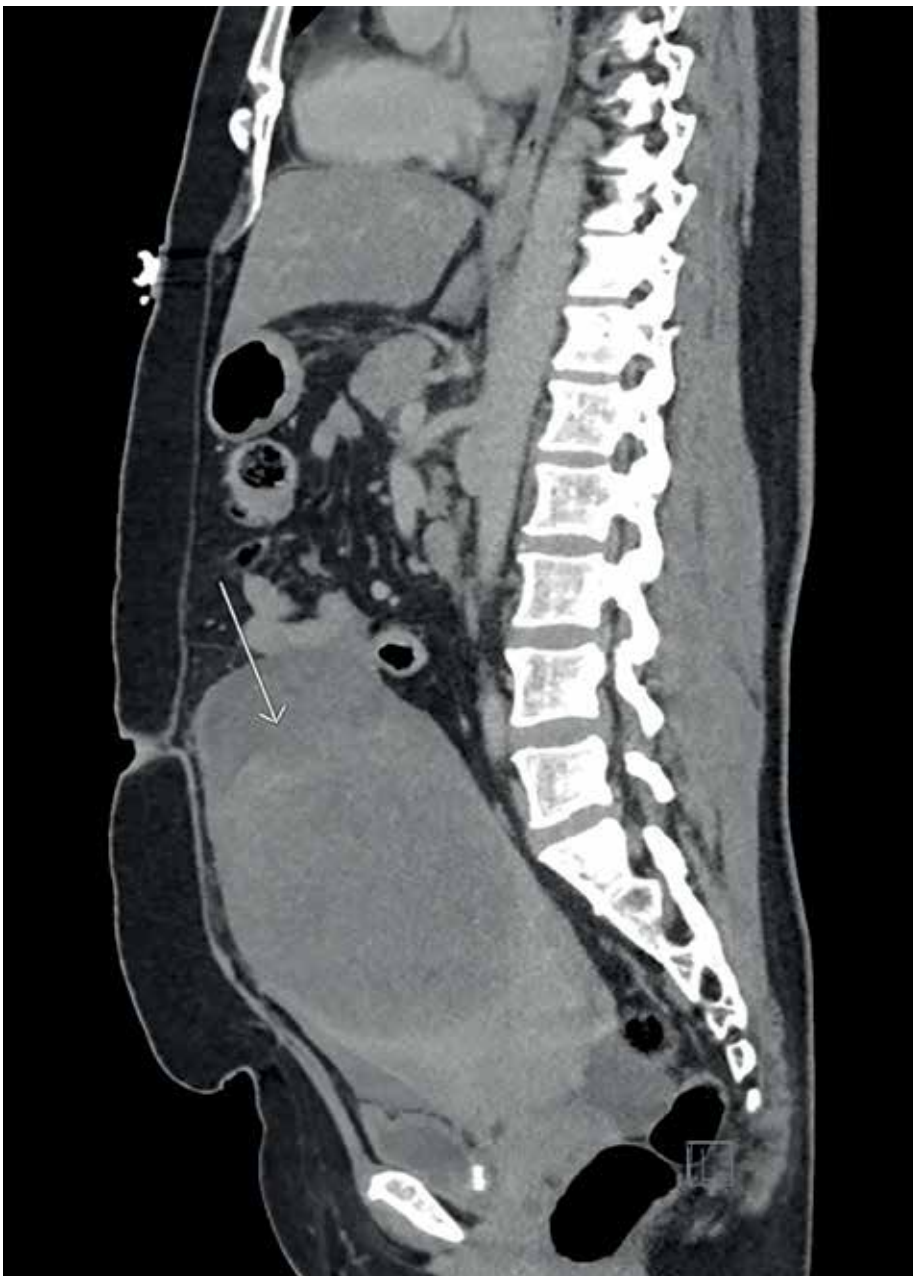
CT scan. Enlarged fibroid uterus..
